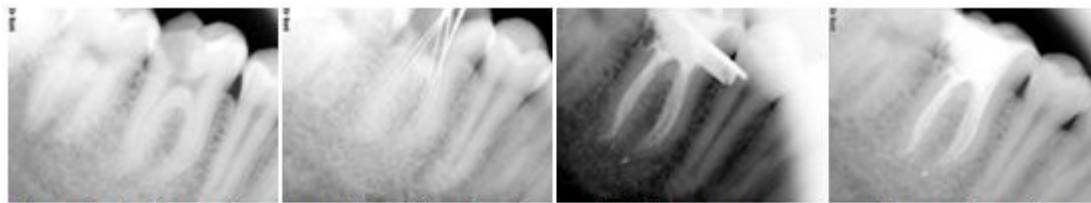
A diagnostic x-ray, B working length C Mastercone D post obturation
